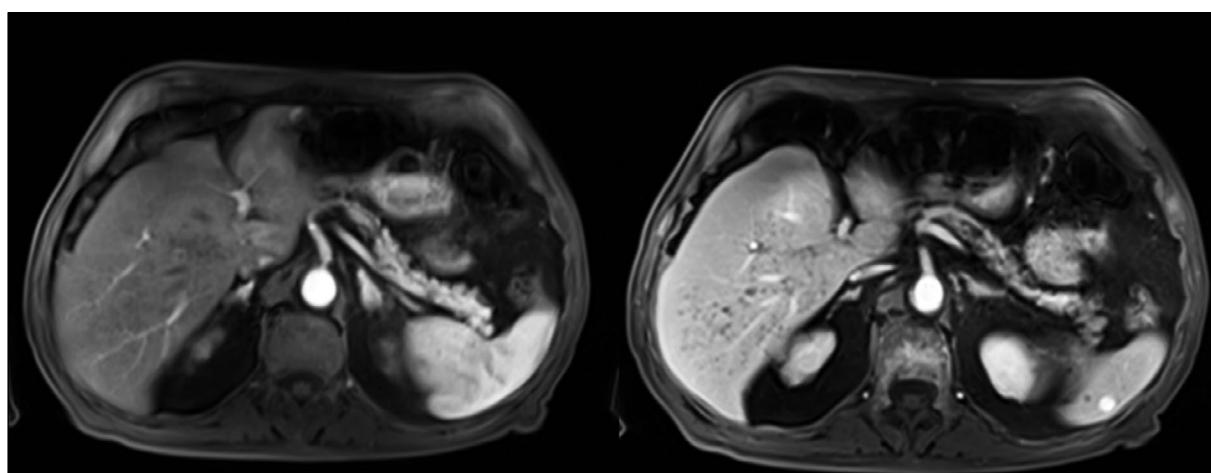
Axial MRI image with T1 sequence showing hypointense lesions without significant contrast enhancement in the arterial and venous phases.
